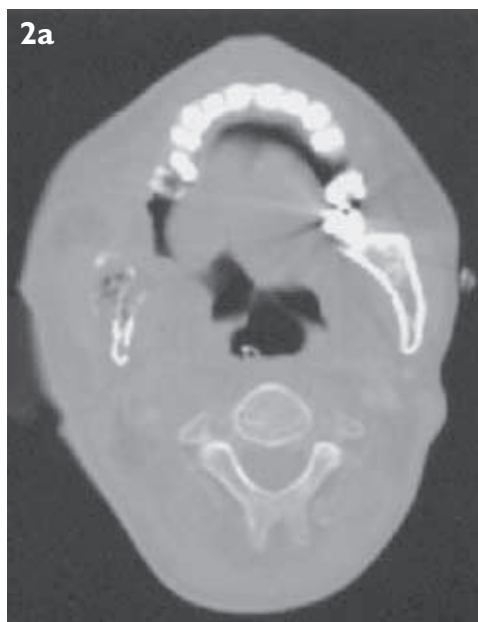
Enhanced axial CT scans of the mandible taken with (a) bone and (b) soft tissue settings.
